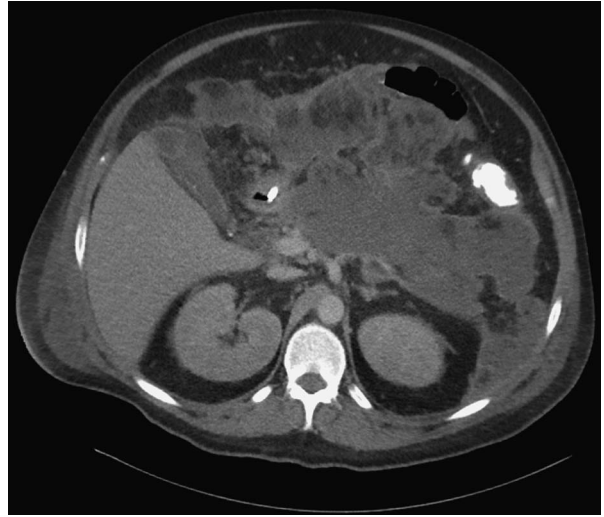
Computed tomography abdomen of the collection before drainage.
